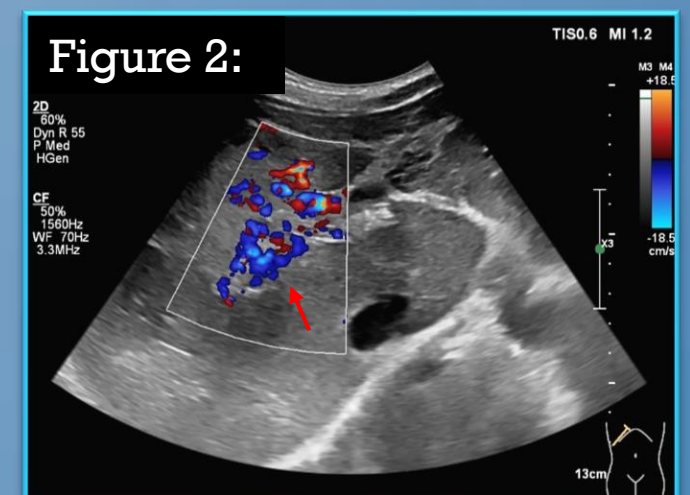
Ultrasound shows no color doppler within the portal vein with adjacent cavernous malformation and collaterals (arrow).
